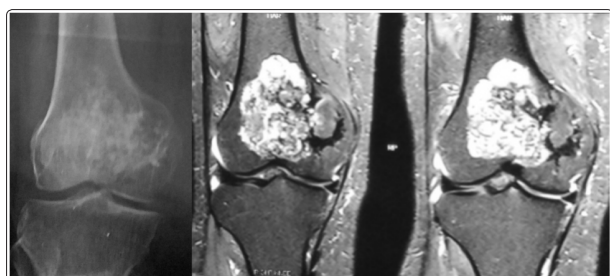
55, F: Chondrosarcoma-Matrix calcification appearing as hypo-intense foci in STIR W MRI; high-signal signify Chondroid matrix
